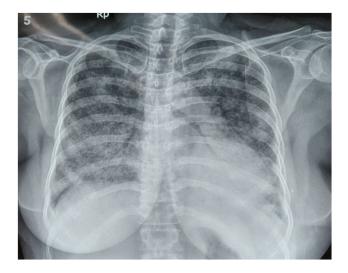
Chest X-ray AP view demonstrating diffuse PAP
